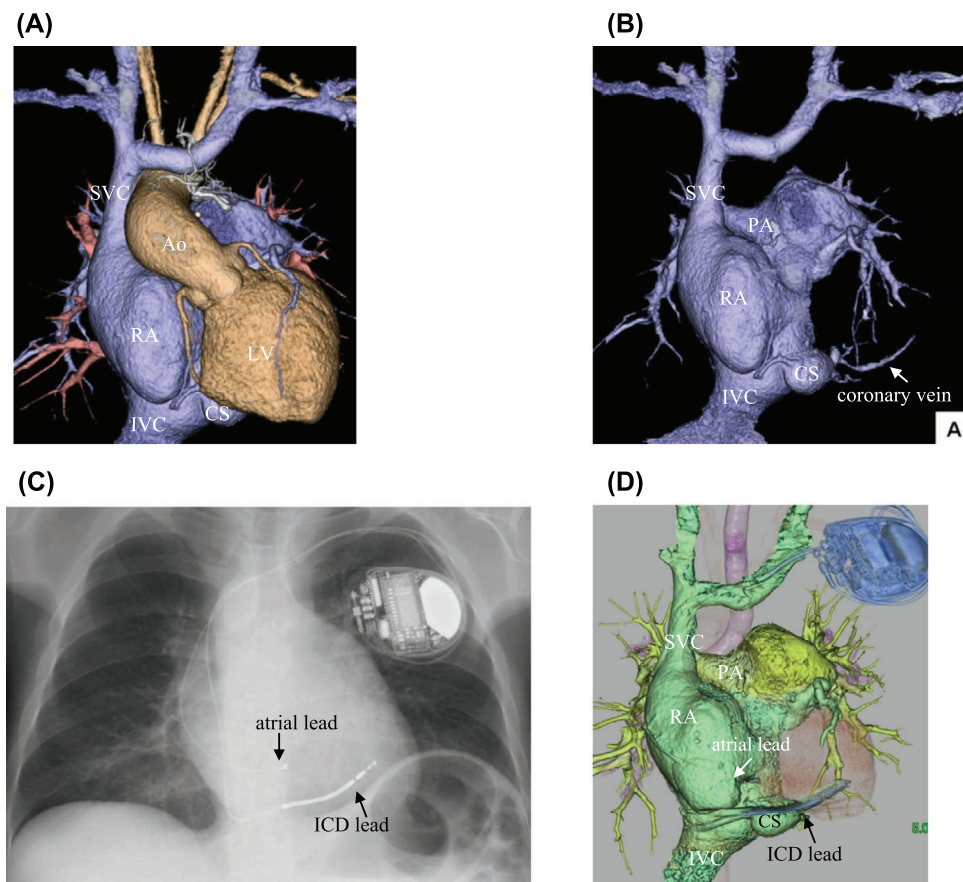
A, Three-dimensional computed tomographic anteroposterior view of the cardiac chambers and aorta (Ao). B, Three-dimensional computed tomographic anteroposterior view of the dilated right atrium (RA), dilated coronary sinus (CS), and small posterior coronary vein. C, Chest radiograph in the anteroposterior view after successful atrial and ventricular pacing through the coronary vein. The white arrow shows the atrial lead. The black arrow shows the implantable cardioverter defibrillator (ICD) lead. D, Three-dimensional computed tomographic anteroposterior view after the device implantation. The white arrow shows the atrial lead. The black arrow shows the ICD lead. Abbreviations: IVC, inferior vena cava; LV, left ventricle; PA, pulmonary artery; SVC, superior vena cava [Color figure can be viewed at wileyonlinelibrary.com]
